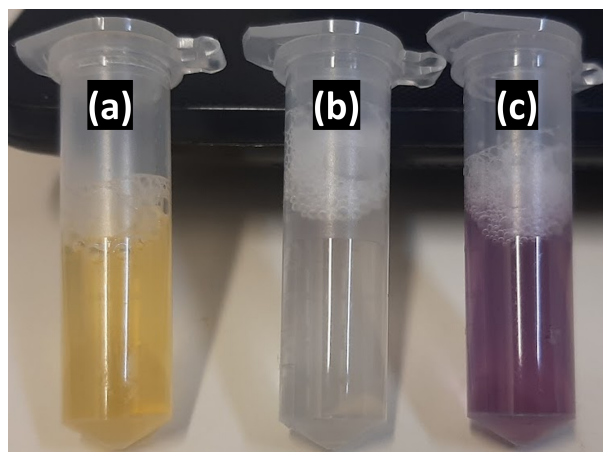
Variation of the samples color after (a) mixture with CTAB; (b) addition of AA; and (c) irradiation with the 48 kVp X-ray beam
